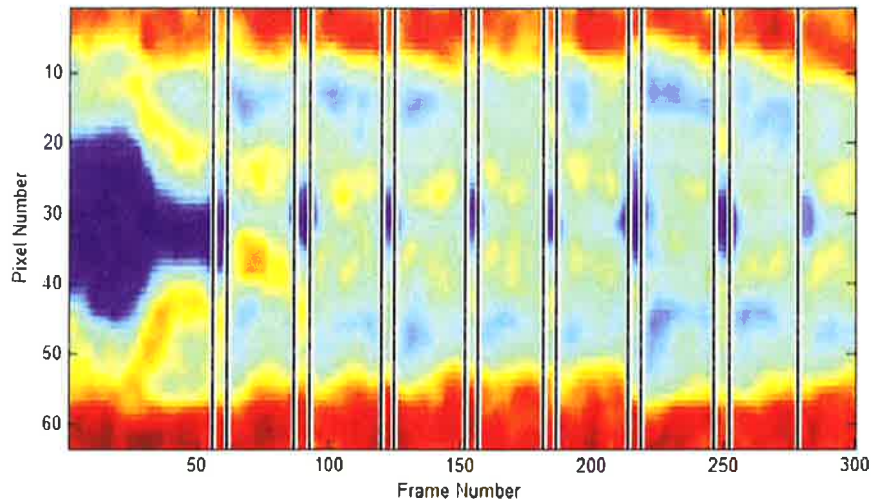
MATLAB image of glottal movement during performance of a repeated staccato note (C4, 262 Hz) on an MRI-compatible trumpet. Sampling period is 10 sec. (See text for details.)
